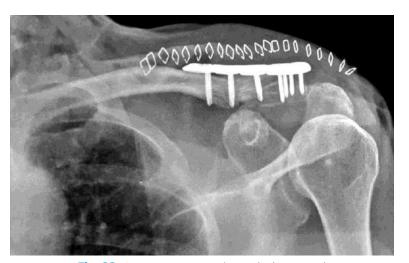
A postoperative radiograph shows good placement of the plate and reduction.
